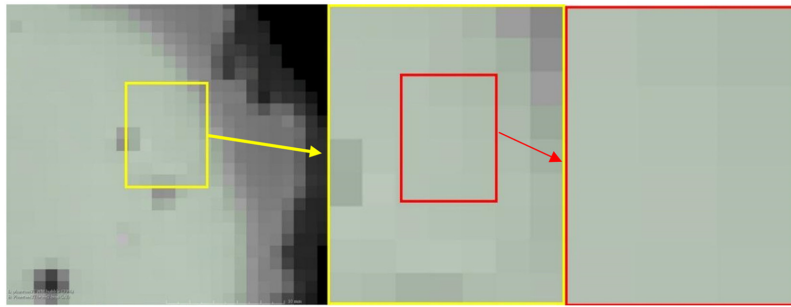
A part of the axial view of a brain image. Yellow rectangular shows a part of the MRI including two tissues. Red rectangular shows 12 pixels with different intensities. It is difficult for human eyes to choose a very similar pixel in the border for labeling because eyes may not be able to distinguish the difference between them.
